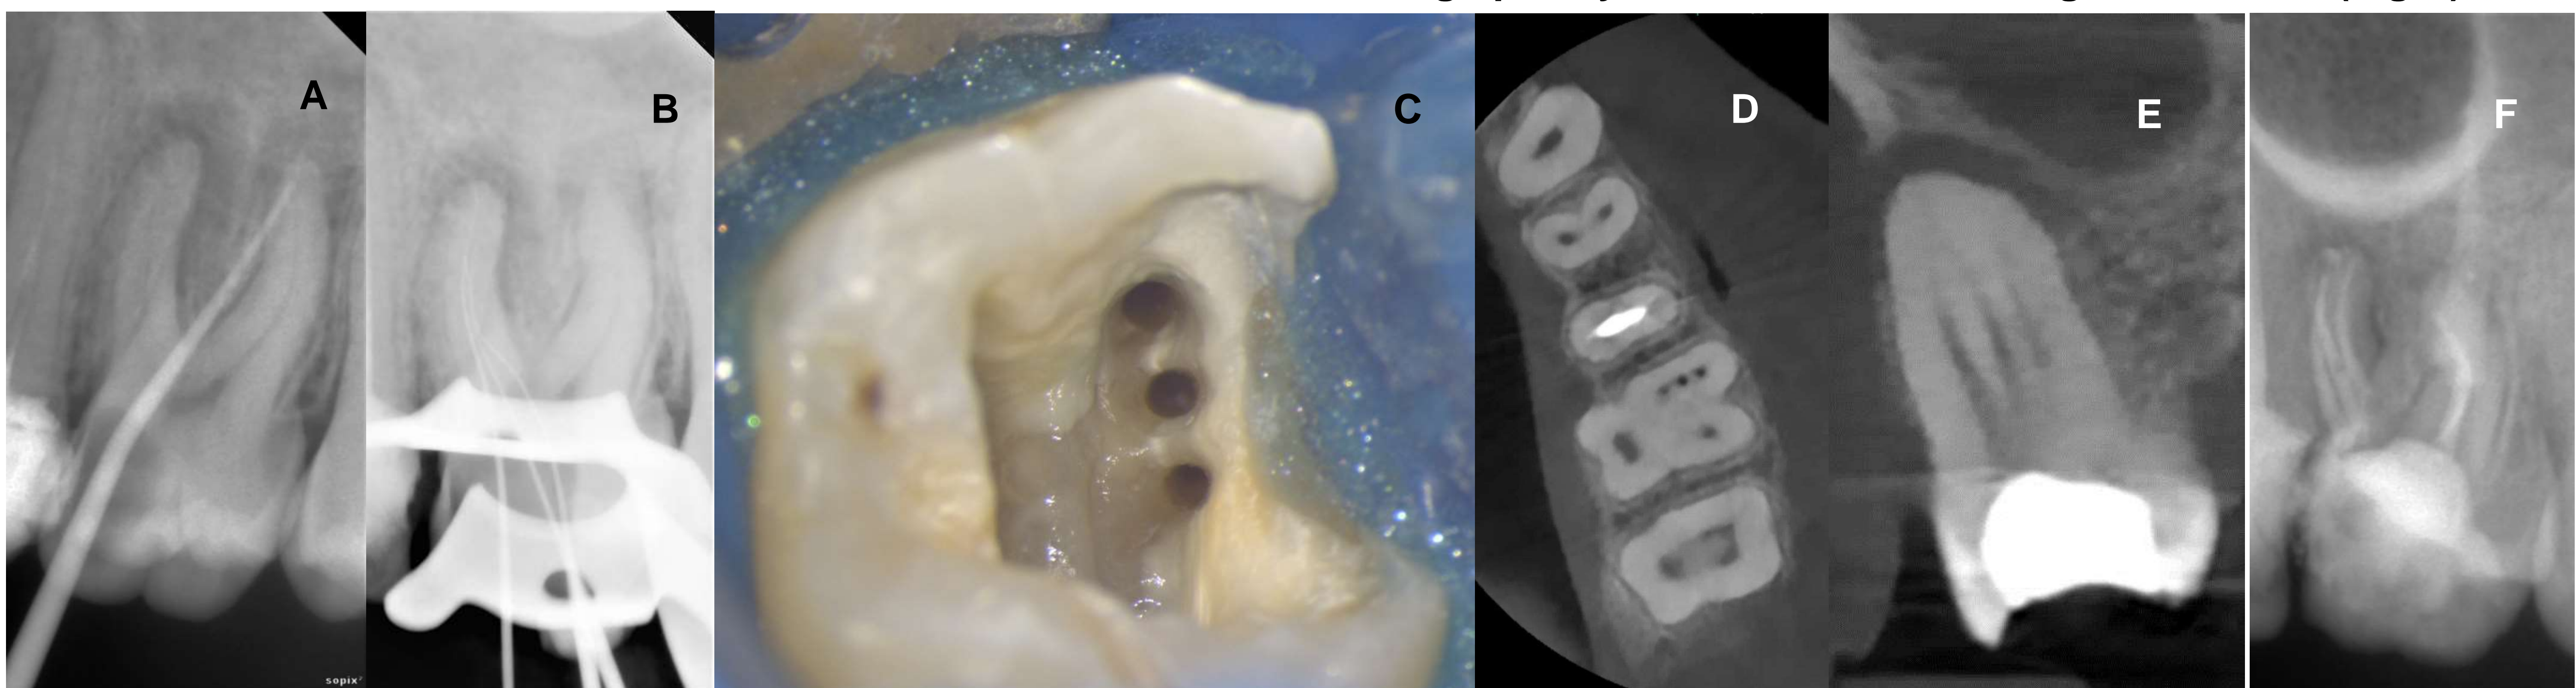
Preoperative periapical image with a tracing test. B: #10 K-file represent three canals in MB root. C: three canal orifices for MB root. D: Coronal and middle third: MB1,MB2,MB3,DB,and P. E: coronal view shows three canals for MB root. F: Periapical image represent five obturated canals.
